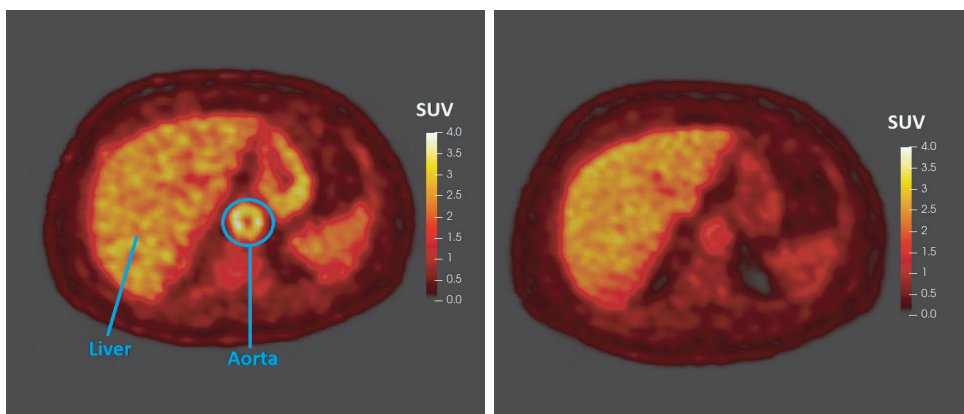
PET slice view of the aorta's highest SUV region before treatment (left) and the corresponding slice after treatment (right).
